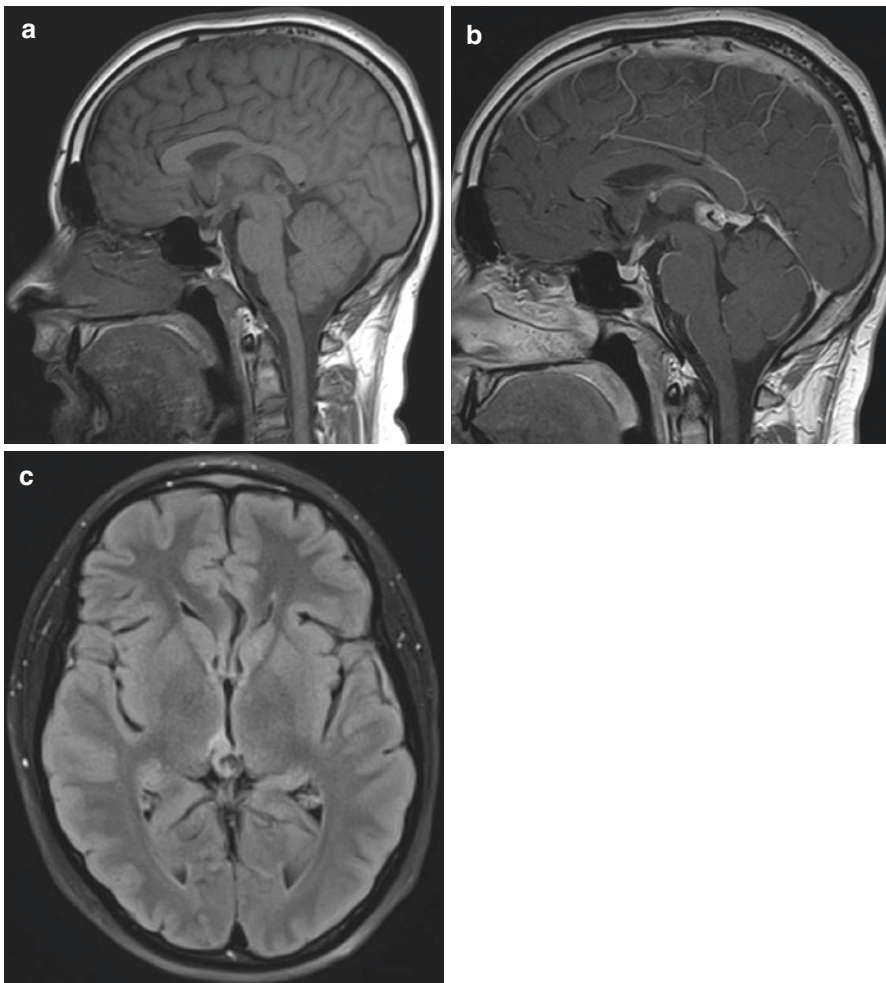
Germinoma in T1WI (a) T1WI with contrast (b), and FLAIR (c) MRI sequences
